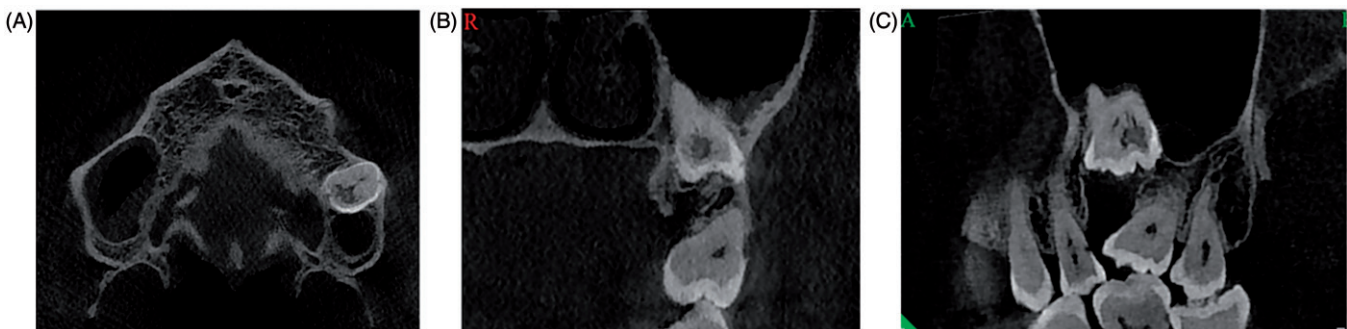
CBCT images; axial (A), coronal (B) and sagittal (C) of the unerupted teeth with PIR defects.
